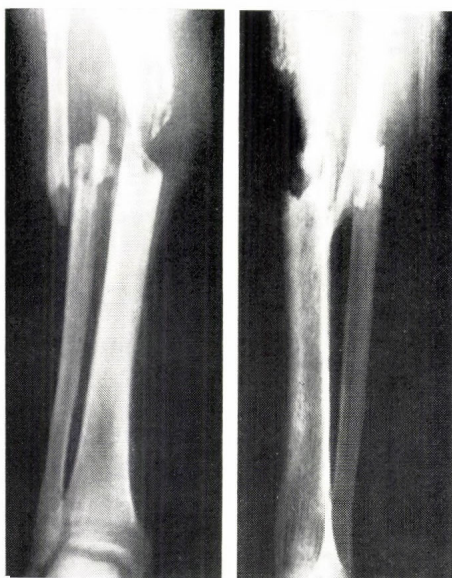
X-ray picture of an open shin-bone fracture with complications
